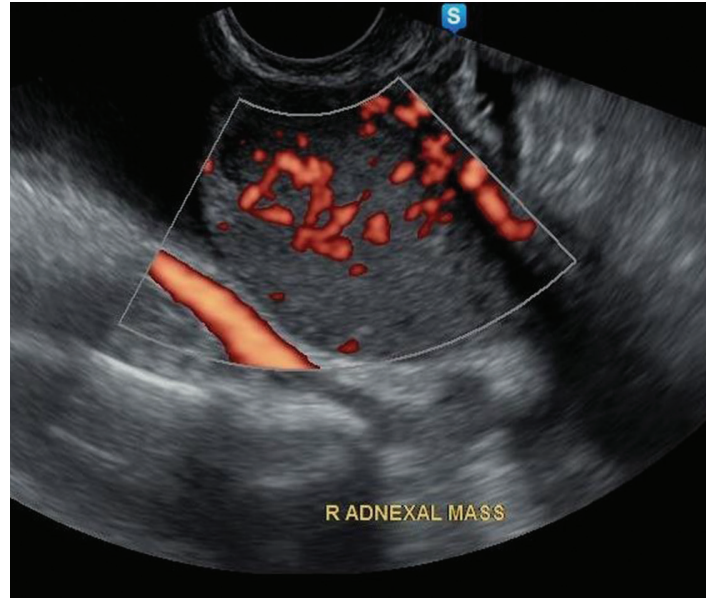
Transvaginal ultrasound showing a solid ovarian mass with abundant central and peripheral branching vascularity (Color Score - 4).
